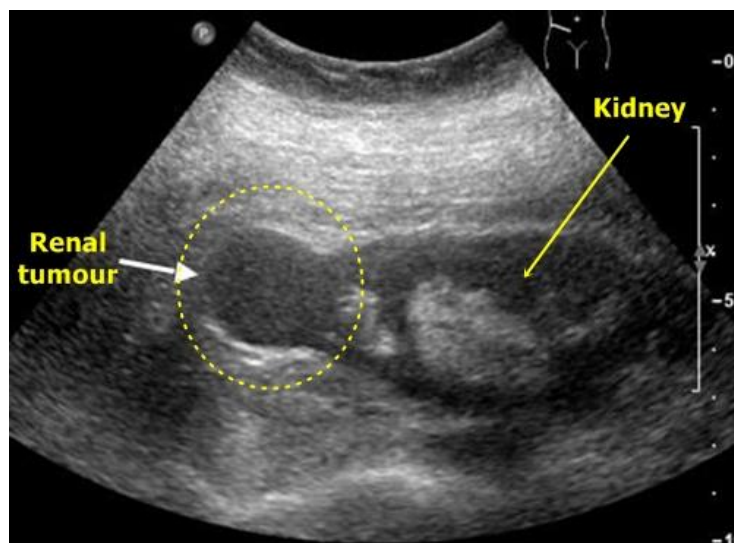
Renal Tumor image using ultrasound
